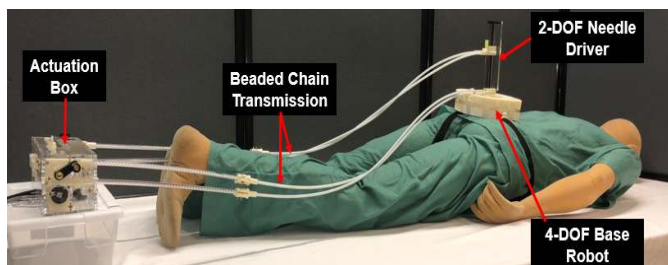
The new robotic system that assists needle steering during MRI-guided intervention for pain management. The 2-DOF needle driver is attached onto the current version of our 4-DOF base robot, and aims toward a 6-DOF robotic platform. The needle driver is remotely actuated by the actuation box through beaded chain transmission.
